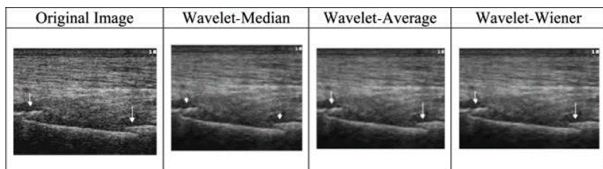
Fibula fracture ultrasound image.
